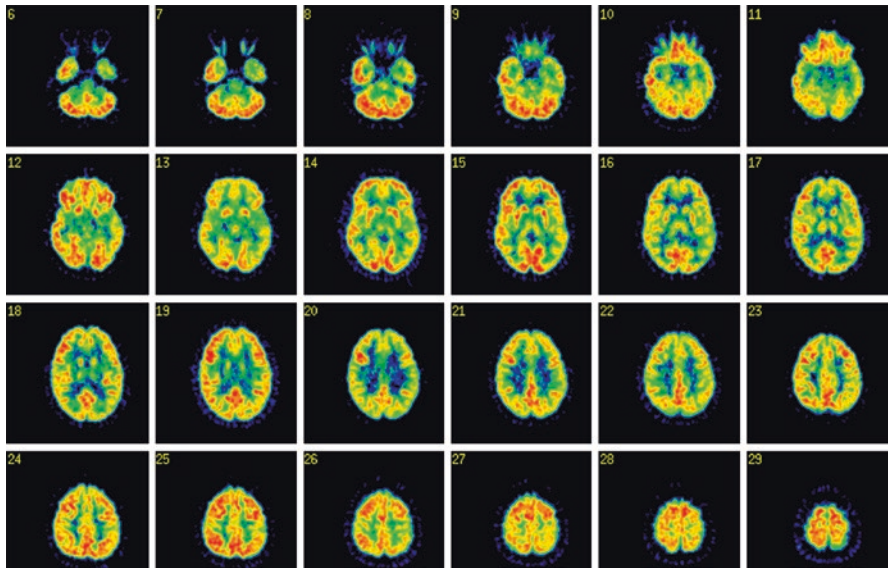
FDG-PET scan showing left temporal hypometabolism in a patient with focal dyscognitive seizures of left mesial temporal onset
